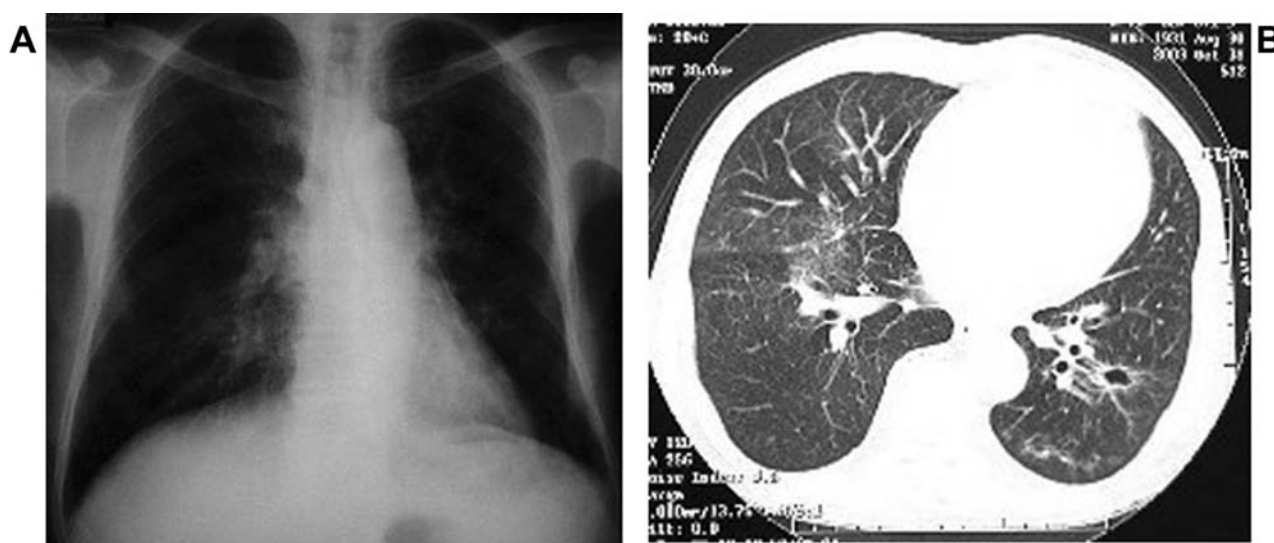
Chest radiograph (A) and chest CT scan (B) after gefitinib treatment showed a decrease of cavity lesion and a disappearance of multiple small nodular opacities in the left S9.
